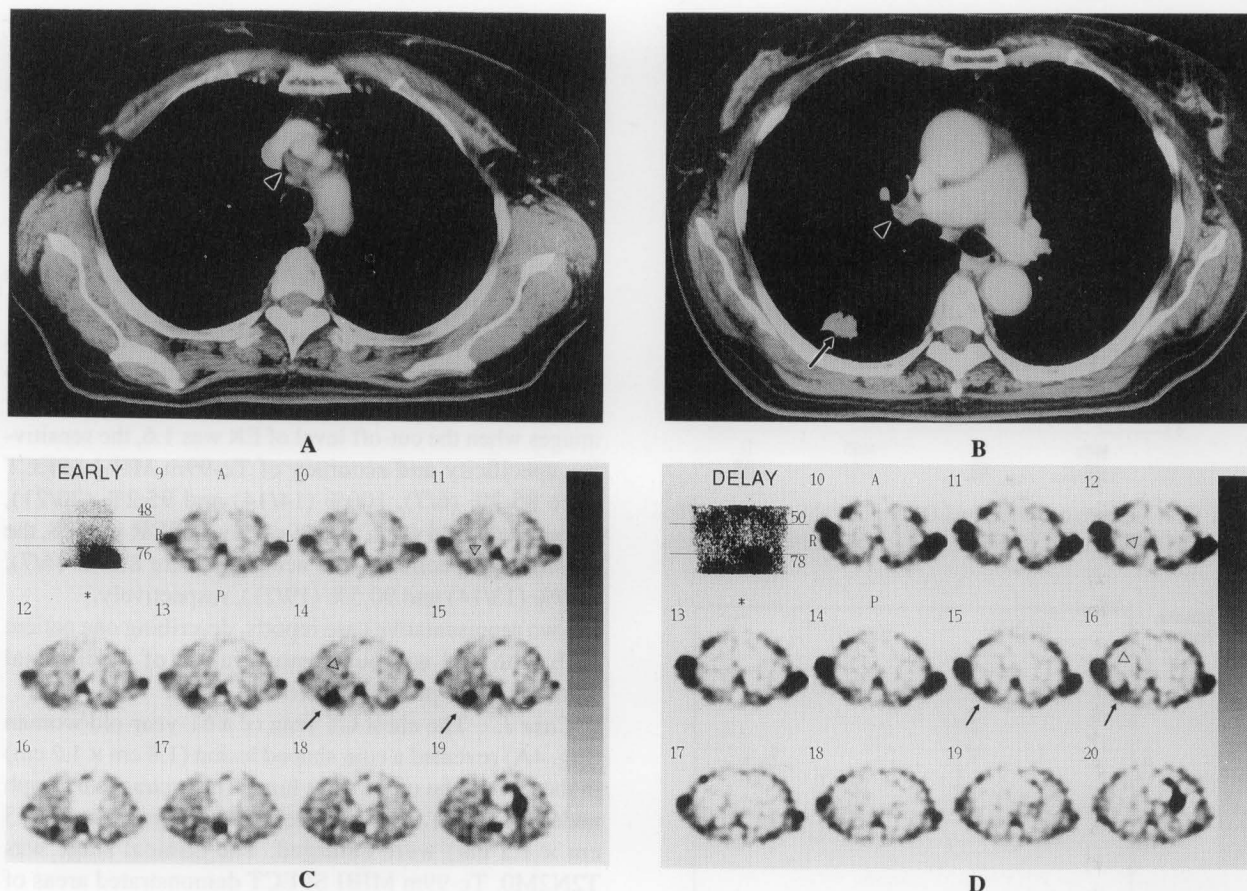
A 61-year-old woman with adenocarcinoma at the right S⁶ (1.8 × 1.2 cm) and enlarged pretracheal and hilar lymph nodes (both, 1.4 × 1.0 cm) (pT2N0M0). Chest CT (A, B) discloses a solitary nodule in the right S⁶ (arrow) and enlarged pretracheal and hilar lymph nodes (arrowhead). Tc-99m MIBI early images (C) show abnormal accumulation at the tumor (arrow) and lymph nodes (arrowhead). On the delayed images (D) abnormal accumulation at the tumor (arrow) is seen, but the accumulation at the lymph nodes has been washed out.
